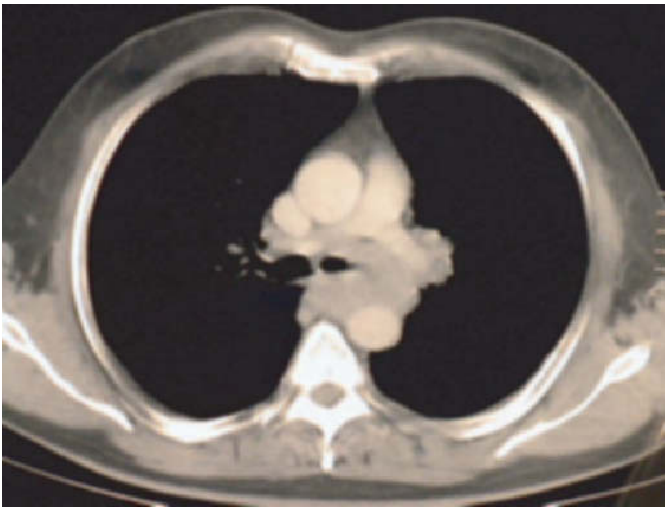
Computed tomography scan with mass in subcarinal and AP window (stations 4 and 8).
